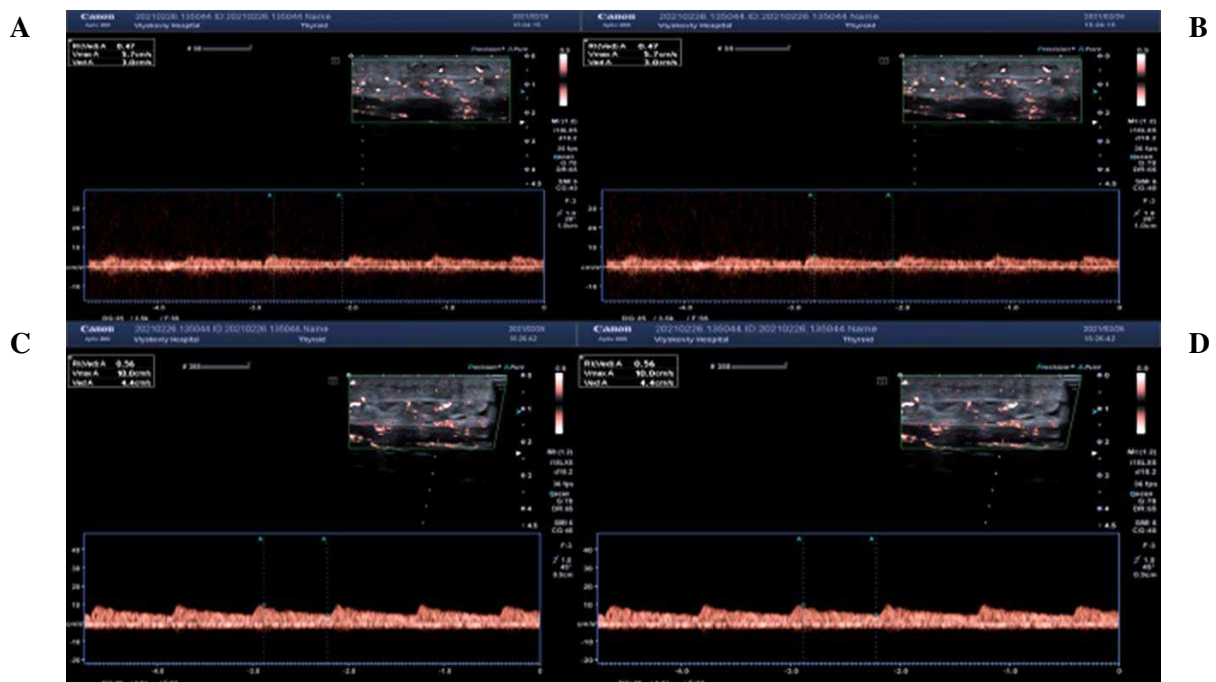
Ultrasonic microvascular imaging using real-time CDS in high image quality of the patient P left (boxes A and C) and right (boxes B and D) legs. A and C: Left leg Doppler ultrasonography at the level of the middle and lower third of the left shin frontal surface. B and D: Right leg Doppler ultrasonography at the level of the middle and lower third of the left shin frontal surface.
